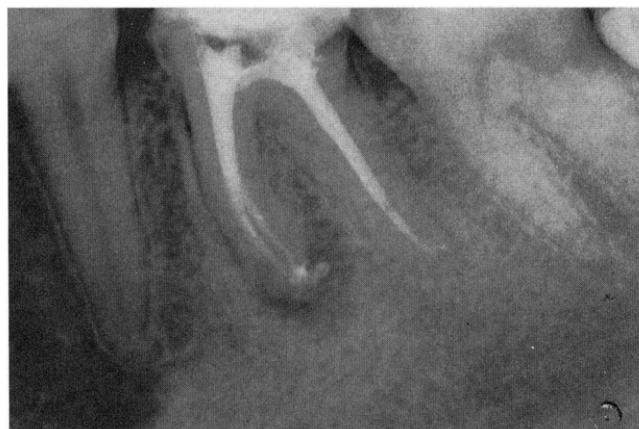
A postoperative radiograph reveals a densely packed root canal system.
